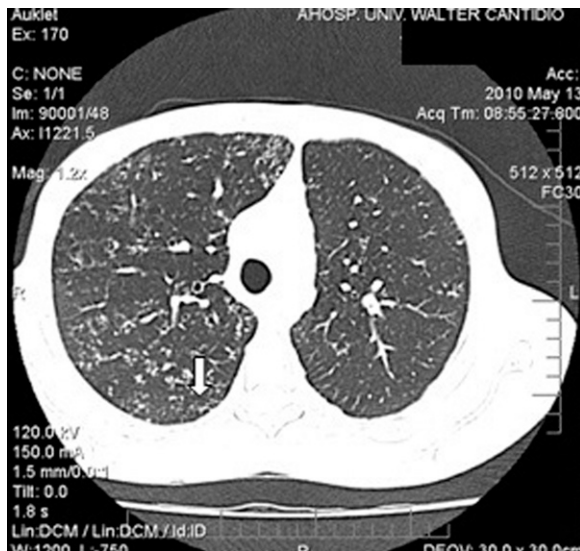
Chest CT scan showing diffuse pulmonary micronodules.
